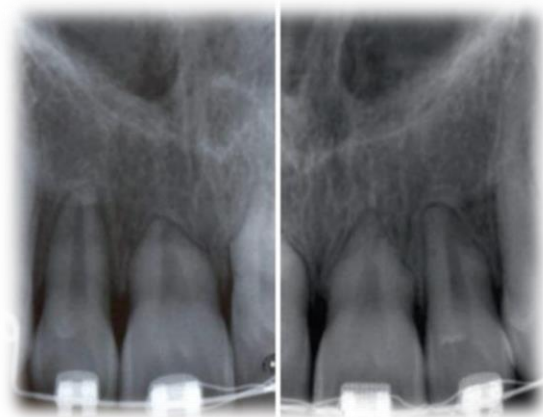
periapical radiographs showing root resorption of upper incisors (Preoteasa *et al.*, 2012).
